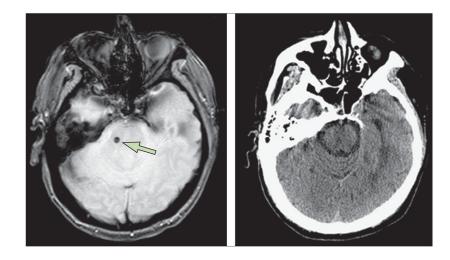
Detection of microhaemorrhages with MRI and CT scans
